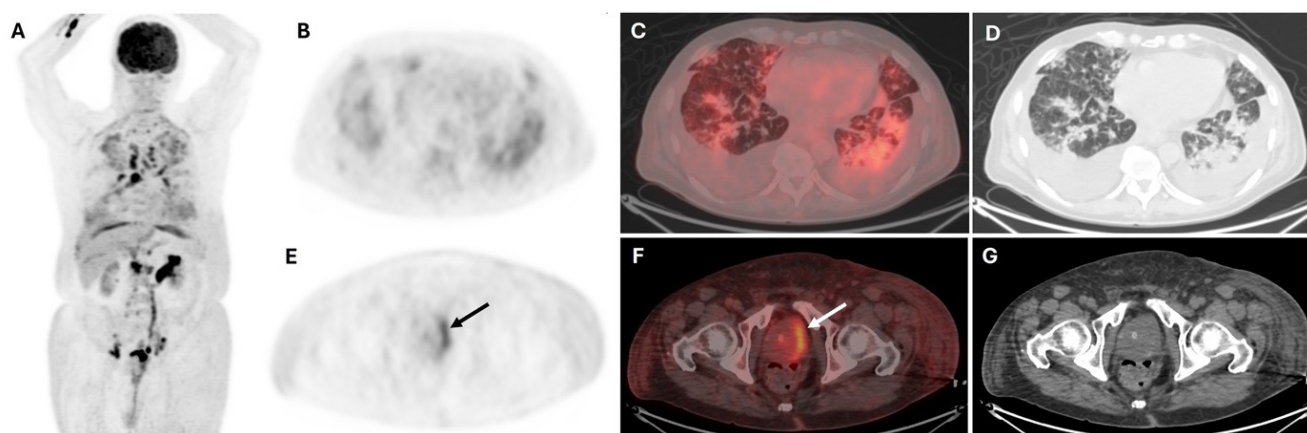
Following an upper respiratory tract infection, a 68-year-old man with progressive exertional dyspnea underwent contrast-enhanced thorax computed tomography (CT) to exclude pulmonary thromboembolism. It was revealed that there was bilateral moderate pleural effusion, enlarged mediastinal lymph nodes, diffuse ground-glass opacities, interlobular septal thickening, consolidations, and atelectasis in bilateral lungs. Although the patient was treated with antibiotics and corticosteroids, the progression of radiological findings was observed in follow-up thorax CT performed due to increasing dyspnea. For further assessment, ^{18}F -Fluorodeoxyglucose positron emission tomography (^{18}F -FDG PET)/CT scan was conducted. It displayed mild to high FDG uptake in multiple mediastinal and intra-abdominal lymph nodes, as well as mild FDG uptake in bilateral lung lesions (A, maximum intensity projection image; B, PET image; C, fused PET/CT image; D, CT image). Mild FDG uptake in the prostate gland (arrow) (maximum standardized uptake values: 5.2), high FDG uptake in the location between the left lateral wall of the urinary bladder and the left side of the prostate gland were incidentally observed (E, PET image; F, fused PET/CT image; G, CT image).
